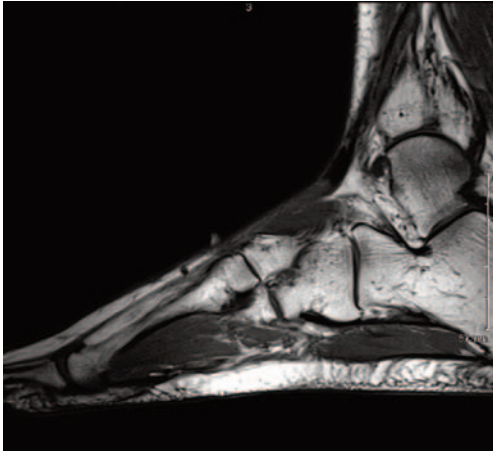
MRI, T1-weighted image at 1 year following treatment.
